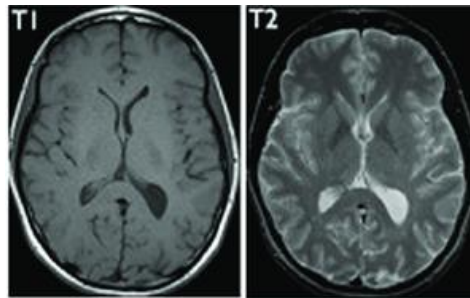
A brain MR image sample in the axial plane, on the left: T_1 weighting, on the right: T_2 weighting. [4]
